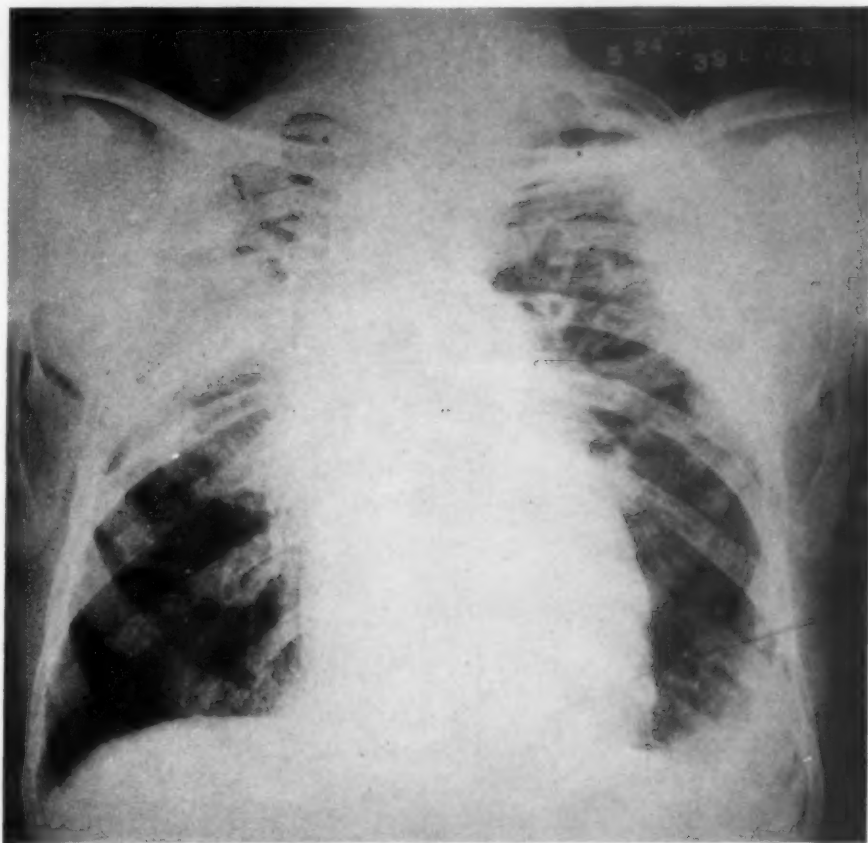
(Case 1.) Roentgenogram taken May 24, 1939. Dense infiltrations throughout the left lung and the upper two thirds of the right lung. The cardiac silhouette is moderately enlarged particularly to the left.
